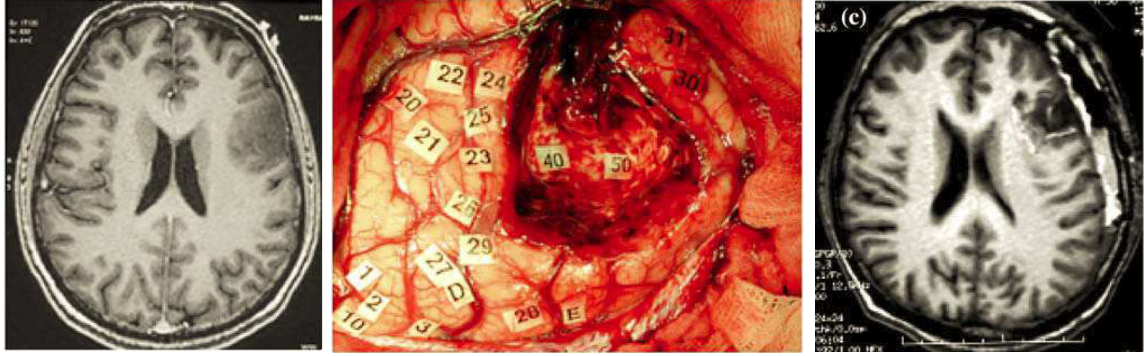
Intraoperative brain mapping. (a) Preoperative MRI, (b) Intraoperative Mapping. Each tag correspond to a functional area that is identified through cortical stimulation, (c) Postoperative MRI. Images extracted from [Duffau 2006]
